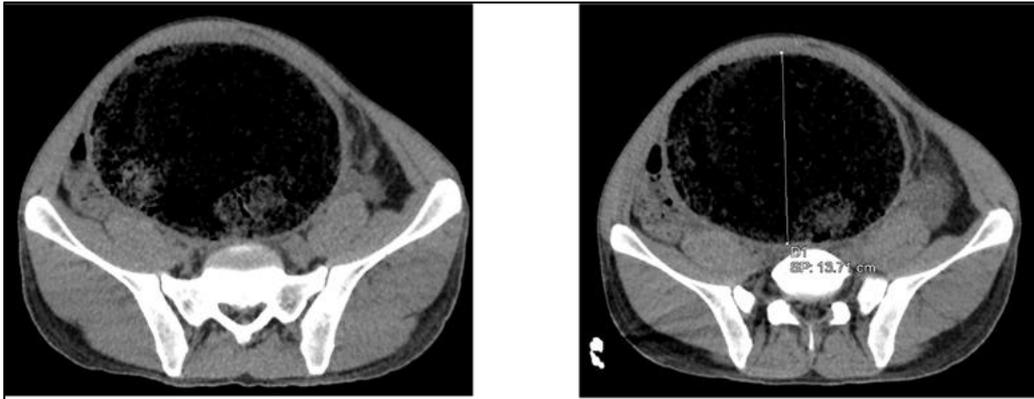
2: CT scan without injection, axial section showing dilatation of the sigmoid to 14 cm
